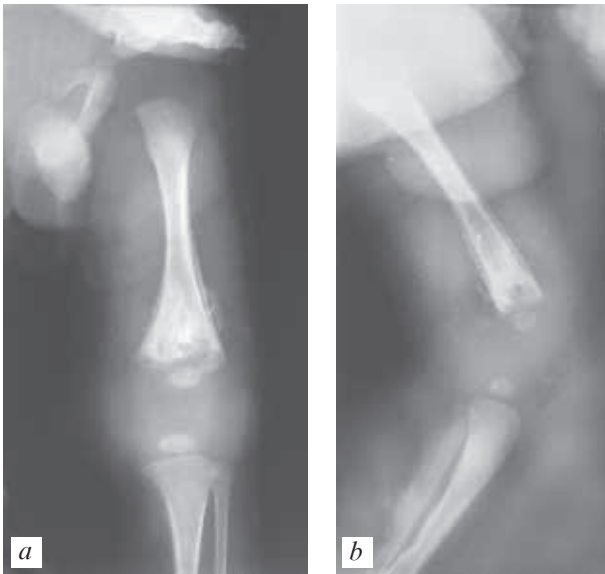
X-ray diagnostics of metaepiphyseal osteomyelitis (a, b)
